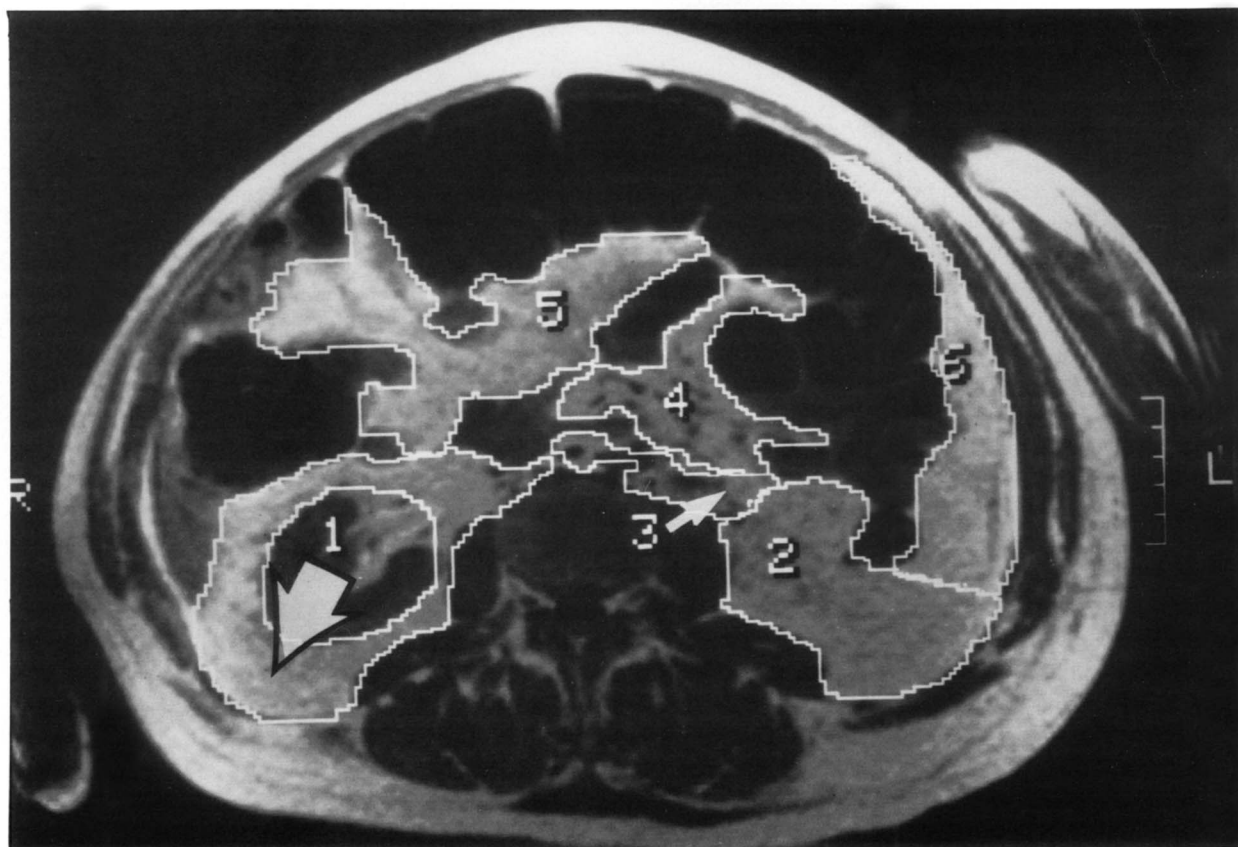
Representative MRI image with outlined intraabdominal adipose tissue compartments. Sections 1, 2, and 3 constitute retroperitoneal adipose tissue. Sections 4, 5, and 6 constitute intraperitoneal adipose tissue.
